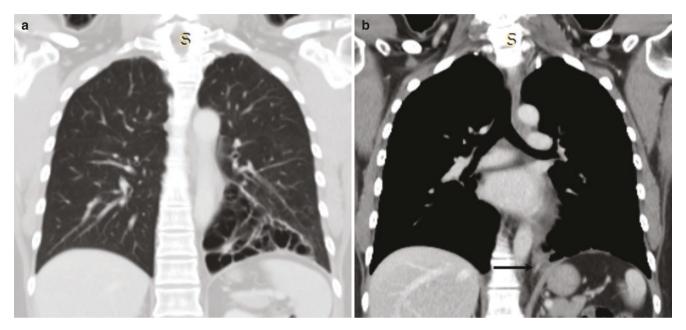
Incidental sequestration in a 69-year-old woman. (a) Coronal CT image shows multicystic changes in the left lower lobe mimicking CCAM. (b) Coronal image in the mediastinal window
